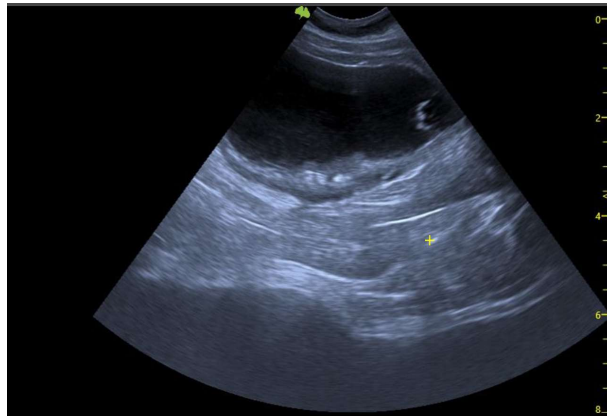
Postoperative bladder ultrasound reexamination results.
